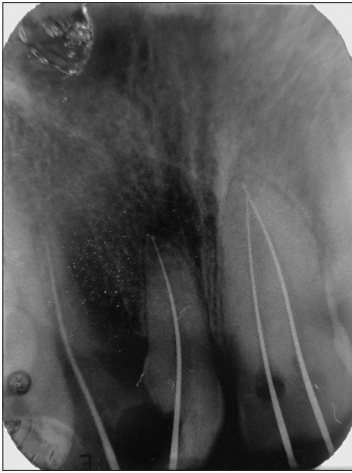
Preoperative radiograph of maxillary anteriors
